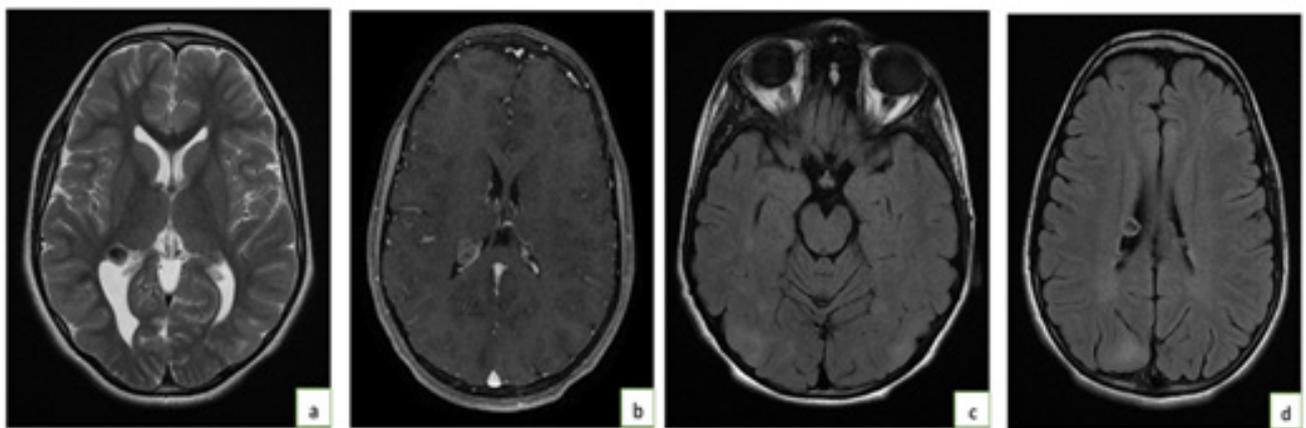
MRI of the axial cut T2 (a) T1 after gadolinium injection (b) showing a giant cell astrocytoma of the right lateral ventricle. axial cut FLAIR (c, d) showing signal abnormalities in relation to cortical tubers.
